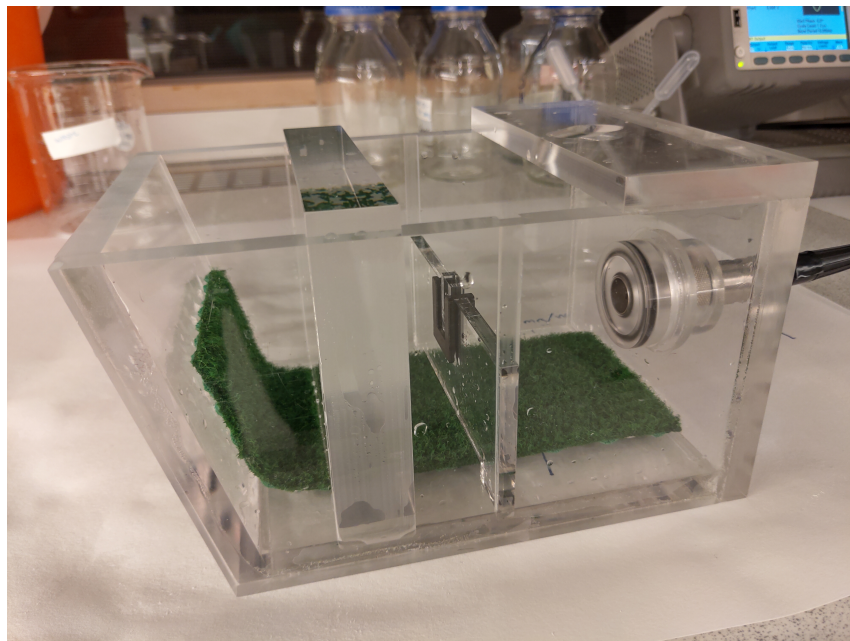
The setup used for the attenuation measurements. The ultrasound is emitted from the transducer on the right, passes through the sample in the middle, and is reflected off the back acrylic wall on the left. The ultrasound then returns the same way it came, back through the sample and is reabsorbed by the transducer. This reabsorption creates an electric signal which is detected on the oscilloscope. Note that the setup shown here is with the old, small, sample holder
